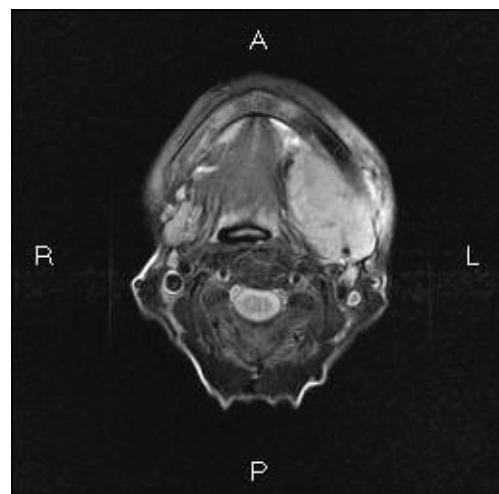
MRI features. A large tumor is seen in the left submandibular gland.
